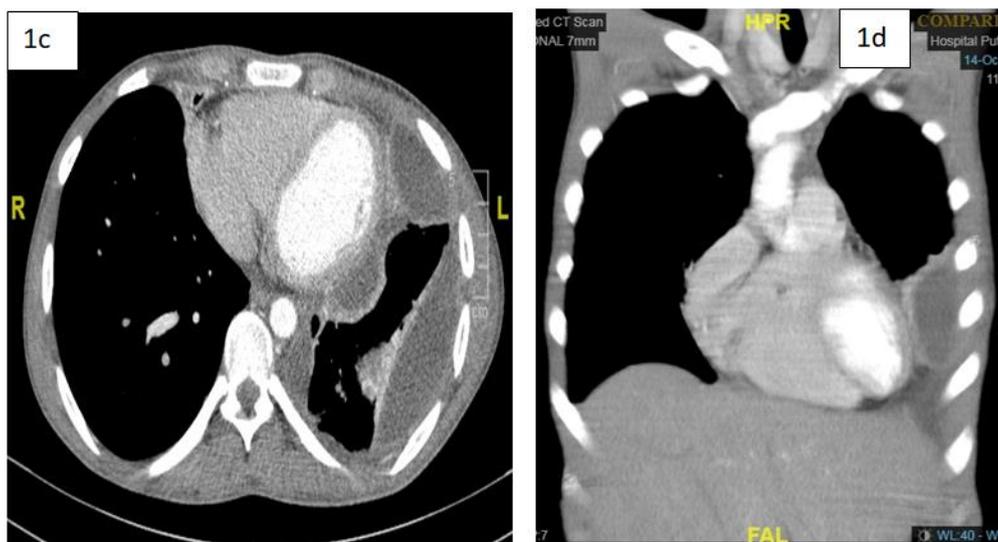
Pre operative CT thorax(axial and coronal views), showing left sided multiloculated pleural effusion with “split pleura” sign
